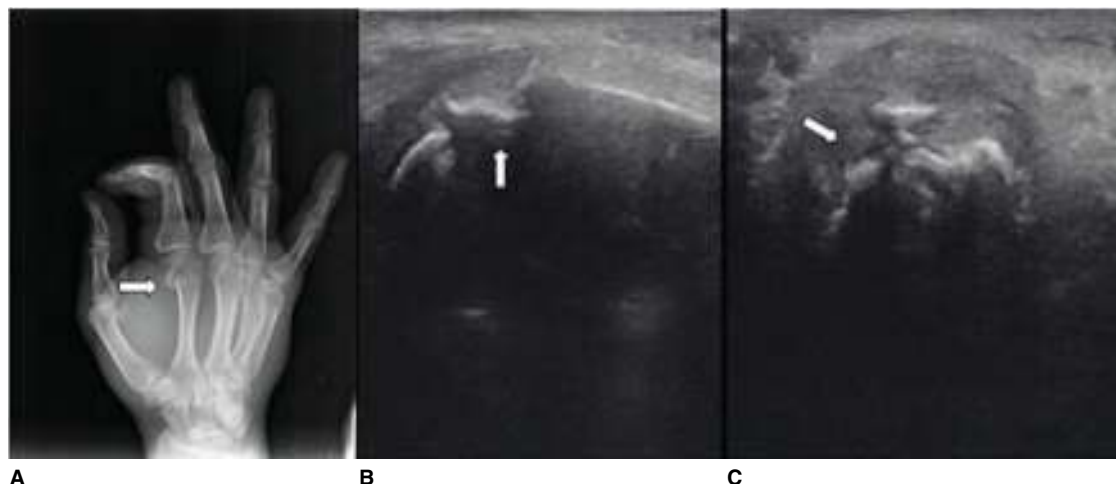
A metacarpal fracture. A. Oblique radiograph. B. Longitudinal US view. C. Transverse US view. (Used with permission from reference 14.)
